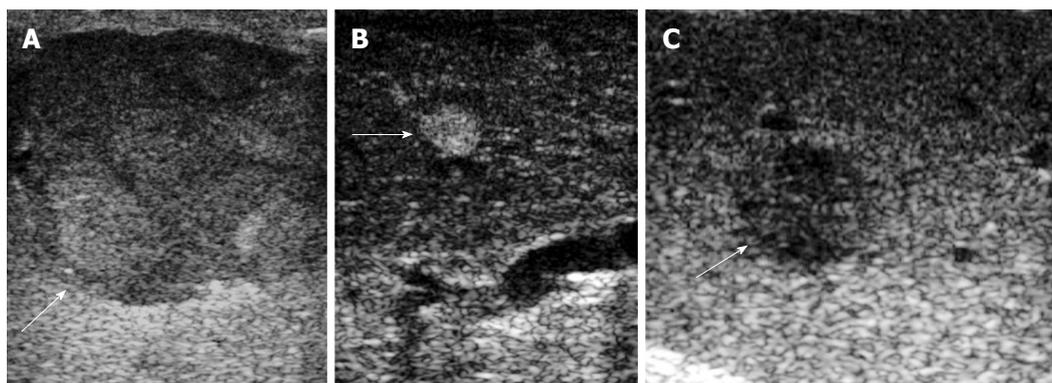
IOUS showing typical sonographic appearance of HCC nodules with mosaic pattern (A, arrow) and hyperechoic regenerative nodules (B, arrow); It is hard for IOUS to accurately diagnose a hypoechoic nodule (C, arrow) which could be a regenerative nodule or a small HCC nodule or focal fatty sparing nodule.
